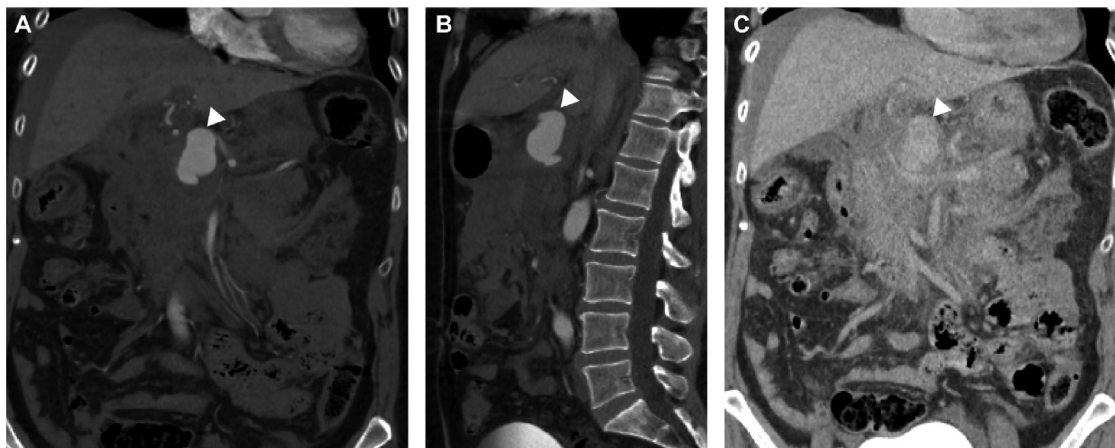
Initial presentation. Slices of contrast-enhanced CT in arterial (A-B) and delayed (C) phase showing ruptured common HAPA (arrowhead, A-C) prior to stent grafting. Ruptured HAPA measuring 4.0 cm × 2.4 cm × 2.3 cm (A-B) impinged on portal venous structures in the porta hepatis (C).
